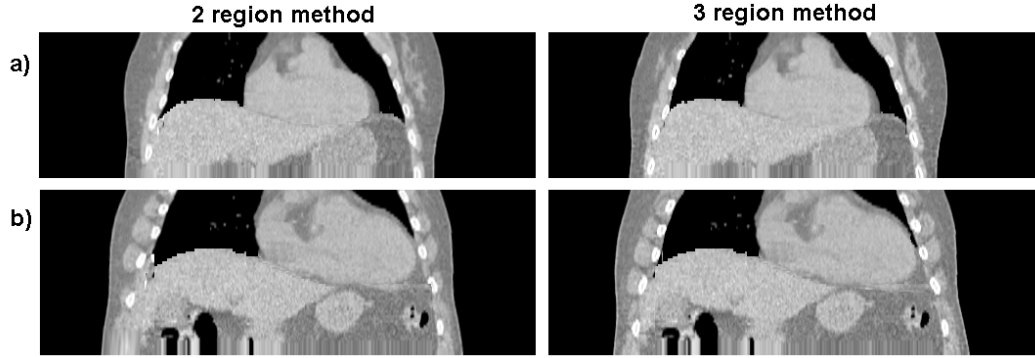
A coronal slice through the end-exhale frame of the transformed CT sets of a) patient 1 and b) patient 2, using the 2 and 3 region methods to divide the CT volume. Both transformed images were obtained using the all-patient model to transform the abdomen region. Please see the animations in Appendix B.3 to view the complete series with all respiratory frames.
